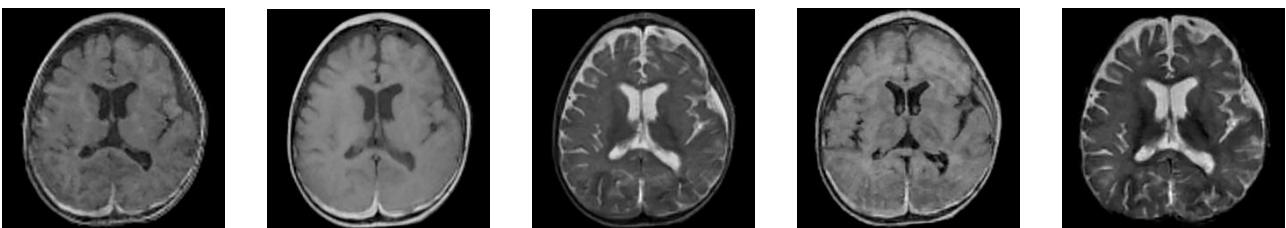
Image contrasts from left to right: MPRAGE, TSE T1, TSE T2, TSE T2 FLAIR, TSE T2 STIR
